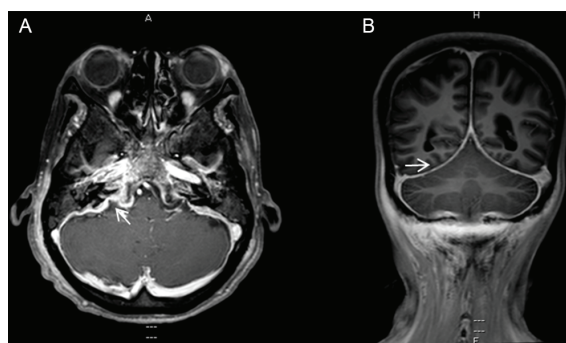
A) Axial T1 post gadolinium MRI showing dural enhancement at right CP angle (arrow). B) Coronal T1 post gadolinium MRI showed diffuse dural enhancement along tentorium cerebelli.
